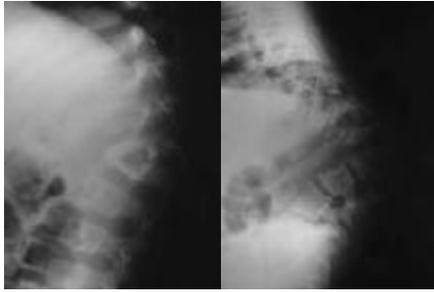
Plain X-rays lateral views showing vertebral destruction with anterior wedge compression leading to severe kyphotic deformity.
